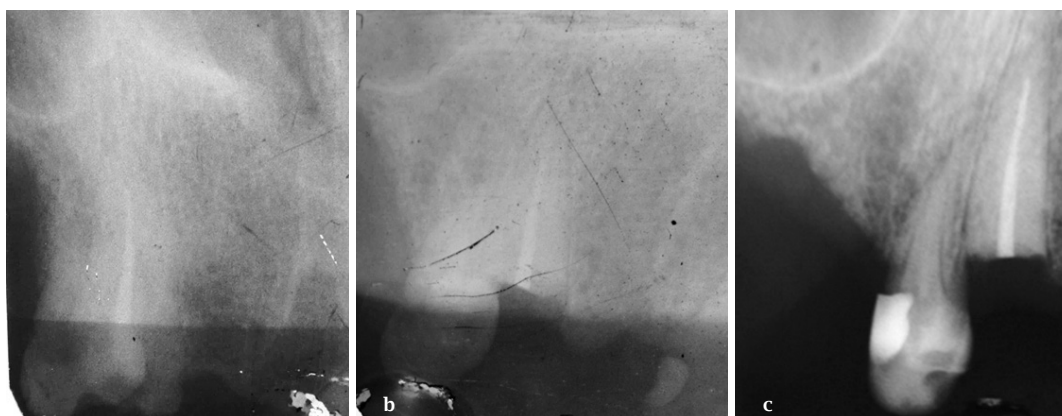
Intraoral Periapical Radiograph (a) Initial (b) Immediately after surgery (c) After six months.
